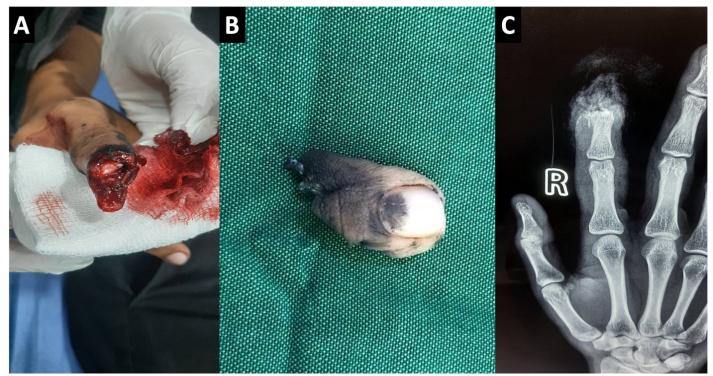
A. Clinical picture showing total traumatic amputation of the index finger. B. amputated stump with greasy materials and dirt. C. X-ray of the same patient showing loss of distal phalanx of the right index finger.
